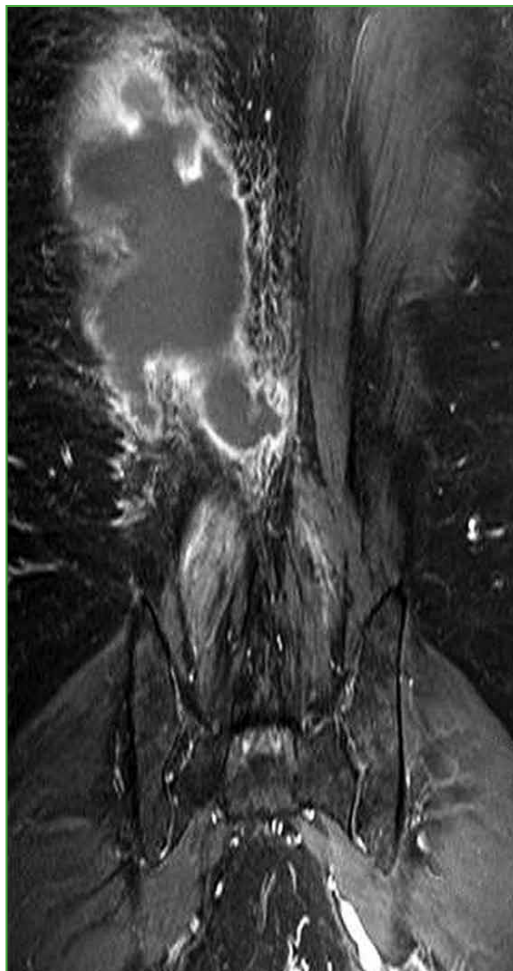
Coronal view of an MRI of the paraspinal muscles showing a fluid collection at the level of the right paraspinal muscles with a diameter of 79 mm (cephalocaudal) x 11 mm (lateral).
